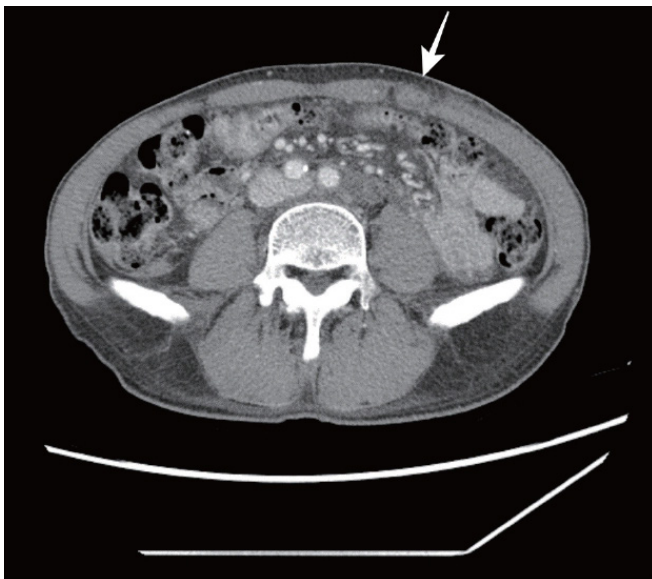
A focal defect (white arrow) was found in the left anterior abdominal wall on the follow-up computed tomographic scan. Written informed consent for the publication of the image was obtained from the patient.
